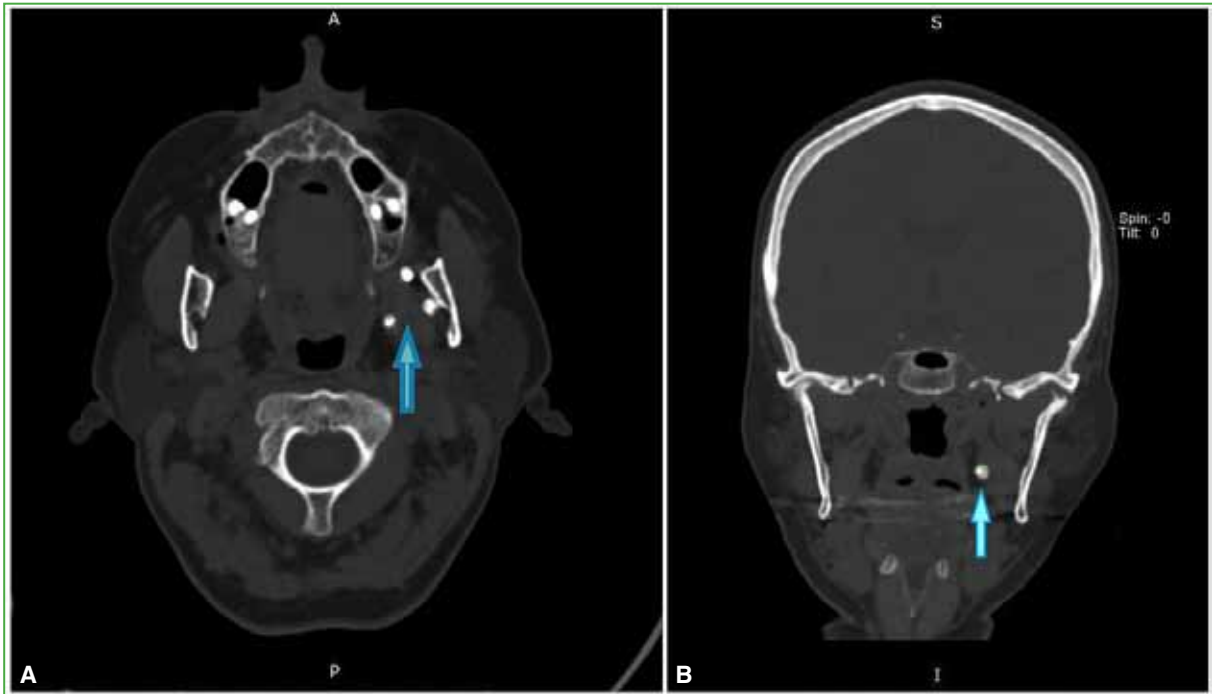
Computed tomography of the craniofacial region. A. Axial reconstruction. B. Coronal reconstruction.
